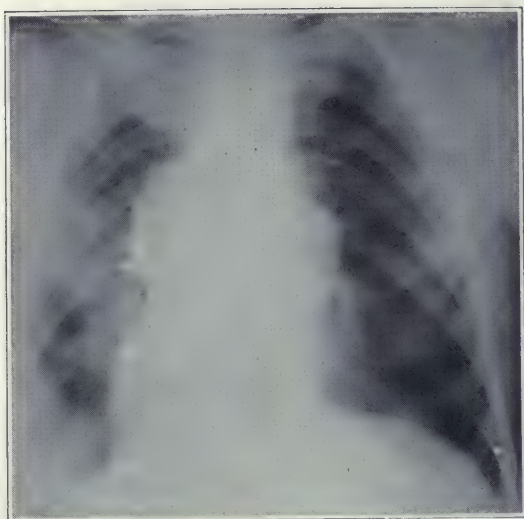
Carcinoma of the mediastinum. A man, aged 53, had dyspnea and dysphagia, with slight dulness at the apices of the lungs and at the left base. Fluoroscopic examination revealed a nonpulsating mass behind the heart, trachea and esophagus, and slight erosion of the bodies of the vertebrae. The roentgenogram showed a large, clearly outlined mass so dense that its borders were seen through the heart. The diagnosis was mediastinal carcinoma.
